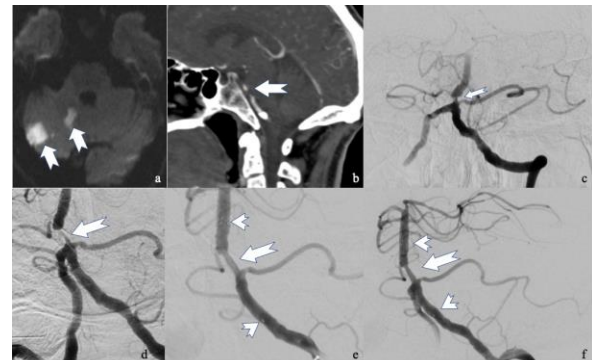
DWI at admission of Case 8, arrows show the acute ischemic lesions, b. Sagittal plane CTA at admission arrow showing critical stenosis at basilar artery, c-d. DSA at coronal plane arrows show critical stenosis at basilar artery, d. DSA after placement stent at coronal plane, e. DSA after post-stent angioplasty, arrows show the opening of stenosis, arrow-heads show stent markers.
